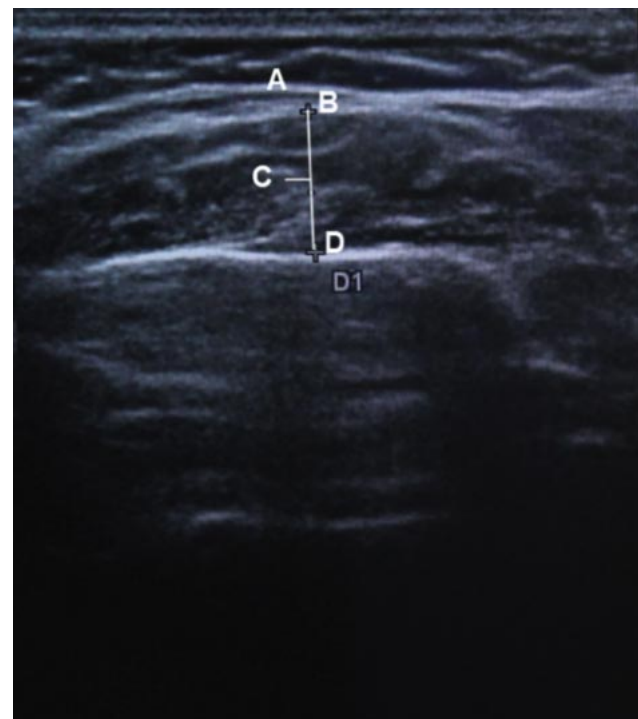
Image obtained by ultrasound.
